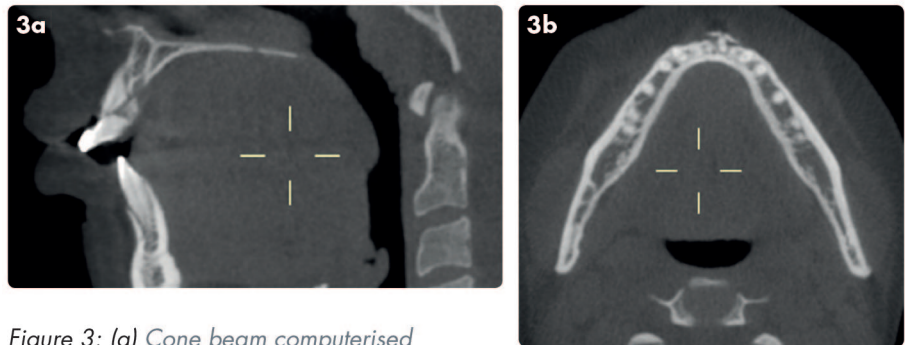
(a) Cone beam computerised tomography (CBCT) sagittal view: complex crown root fracture 21, with comminuted dento-alveolar fracture and loss of labial cortex; (b) CBCT axial view: labial cortex 32–41 comminuted fracture displaced labially
